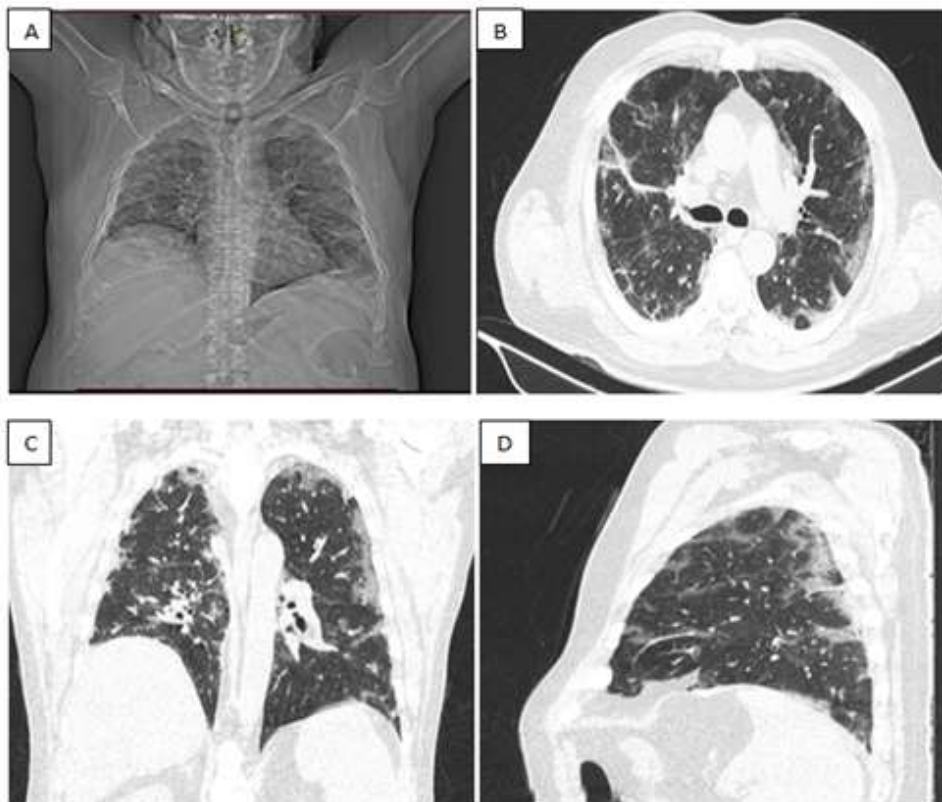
Radiograph (A), and CT axial (B), coronal (C) and sagittal (D) images of a 66 year old male patient showing predominantly peripheral patchy ground glass opacities. The CTSI score of patient was 7/25 (Mild) and SPO2 of patient was 97%.
